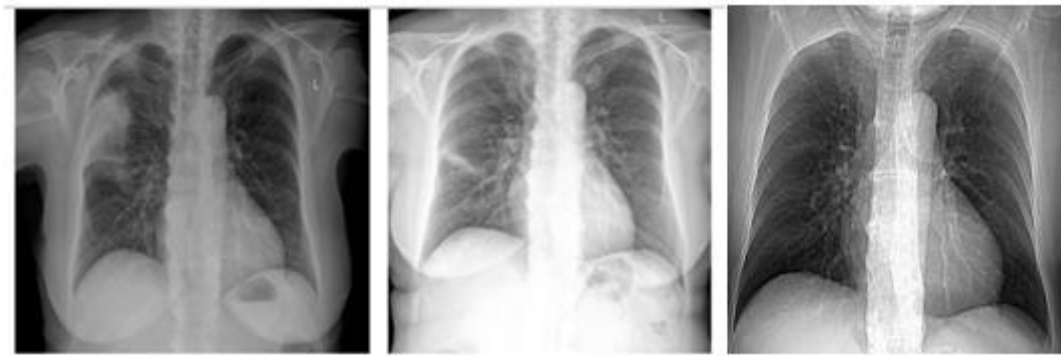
Chest radiographs of Case No. 3 patient, before (on the left), one month after starting corticosteroid therapy (in the middle), and on the annual follow up control (on the right)
